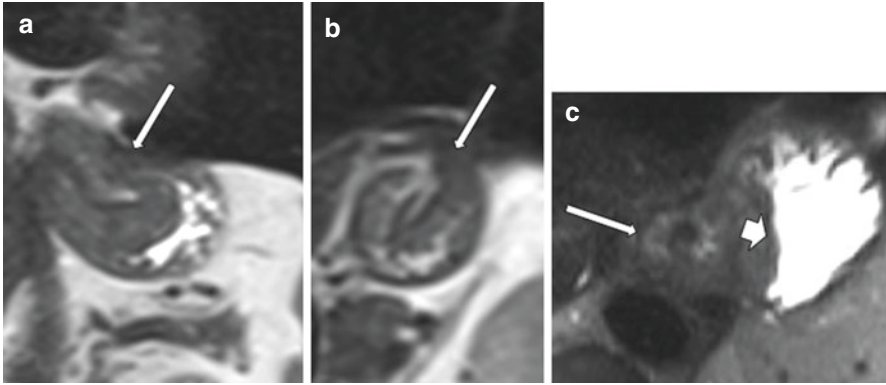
Normal postoperative appearance after Nissen fundoplication on MRI. The coronal (a) and sagittal (b) view shows the correct position of the wrap under the diaphragm. A ring-like “pseudotumor” (long arrow) of the fundoplication, and a well-defined smooth defect in the fundus (short arrow) acquired in the axial plane (c)
